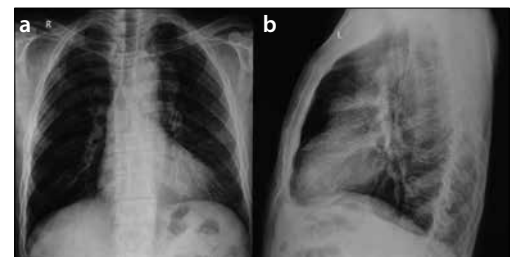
a, b. In the posteroanterior chest X-ray of the patient, an oval mass lesion, the long margin of which extends toward the hilus in the neighborhood of the aortic curve on the left, is seen (a). In the lateral radiography, the lesion is seen in the upper mediastinum (b)
